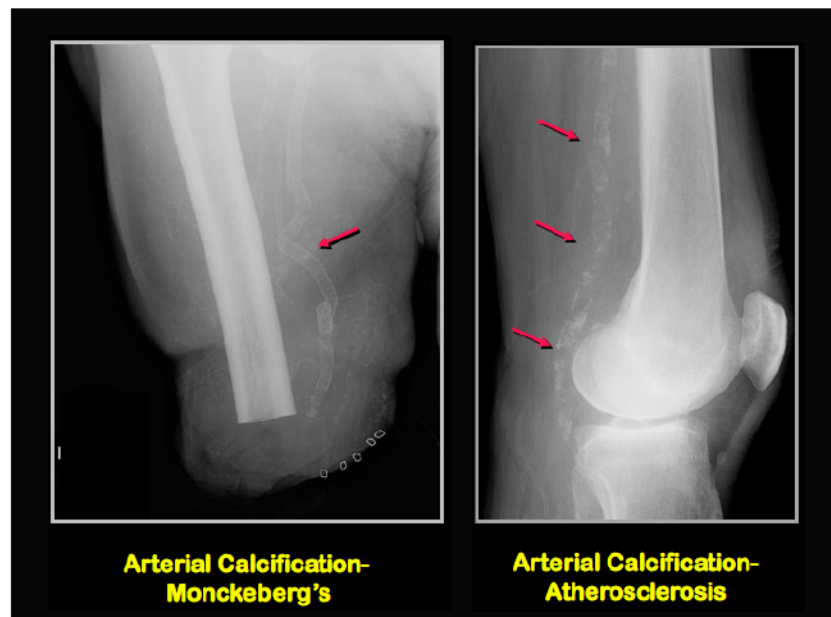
Radiological images of arterial calcification: Fig1a: X-ray image of Mönckeberg's medial calcification; Fig1b: X-ray image of intimal atherosclerotic plaques. Images were taken from Learning Radiology.com
